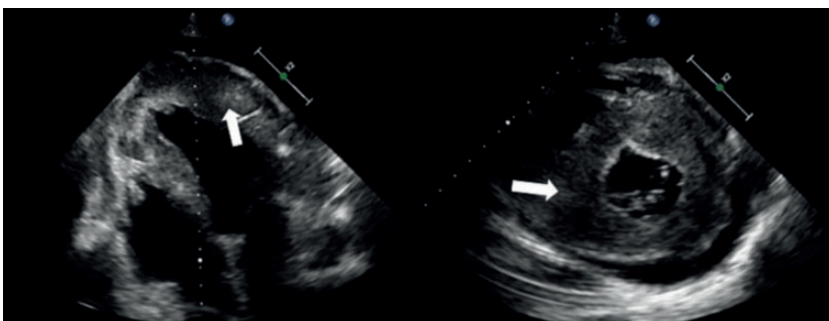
Echocardiography of the four cardiac chambers (left) and short-axis view (right). The left ventricular wall is markedly thickened (arrows).
